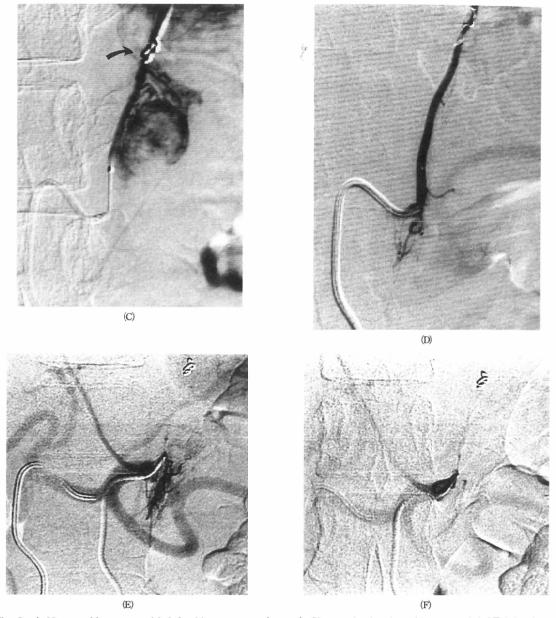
A 28-year-old woman with left aldosteronoma (case 4). She received twice of intraarterial AE injection. Computed tomography taken before (A) and 7 days after the first therapy (B). Adrenal arteriograms performed before (C) and immediately after (D) the first therapy and before (E) and immediately after (F) the second therapy.
